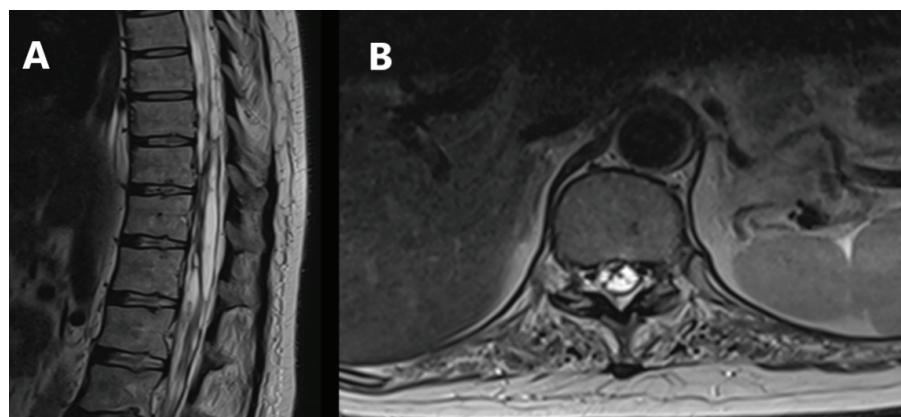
(A and B). MRI of thoracic spine presenting sagittal and axial projections of new TH9-TH12 in T2 sequence
